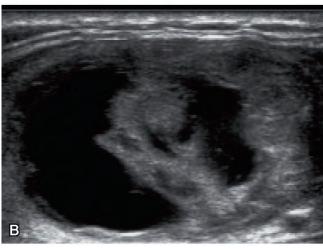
Ultrasound of a colloid nodule in the right lobe. A and B, Transverse. C, Color Doppler, longitudinal.
